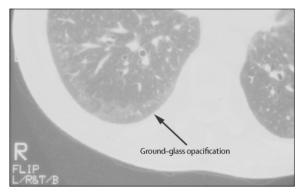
High-resolution CT of the chest showing ground-glass opacities in a patient with diffuse scleroderma
